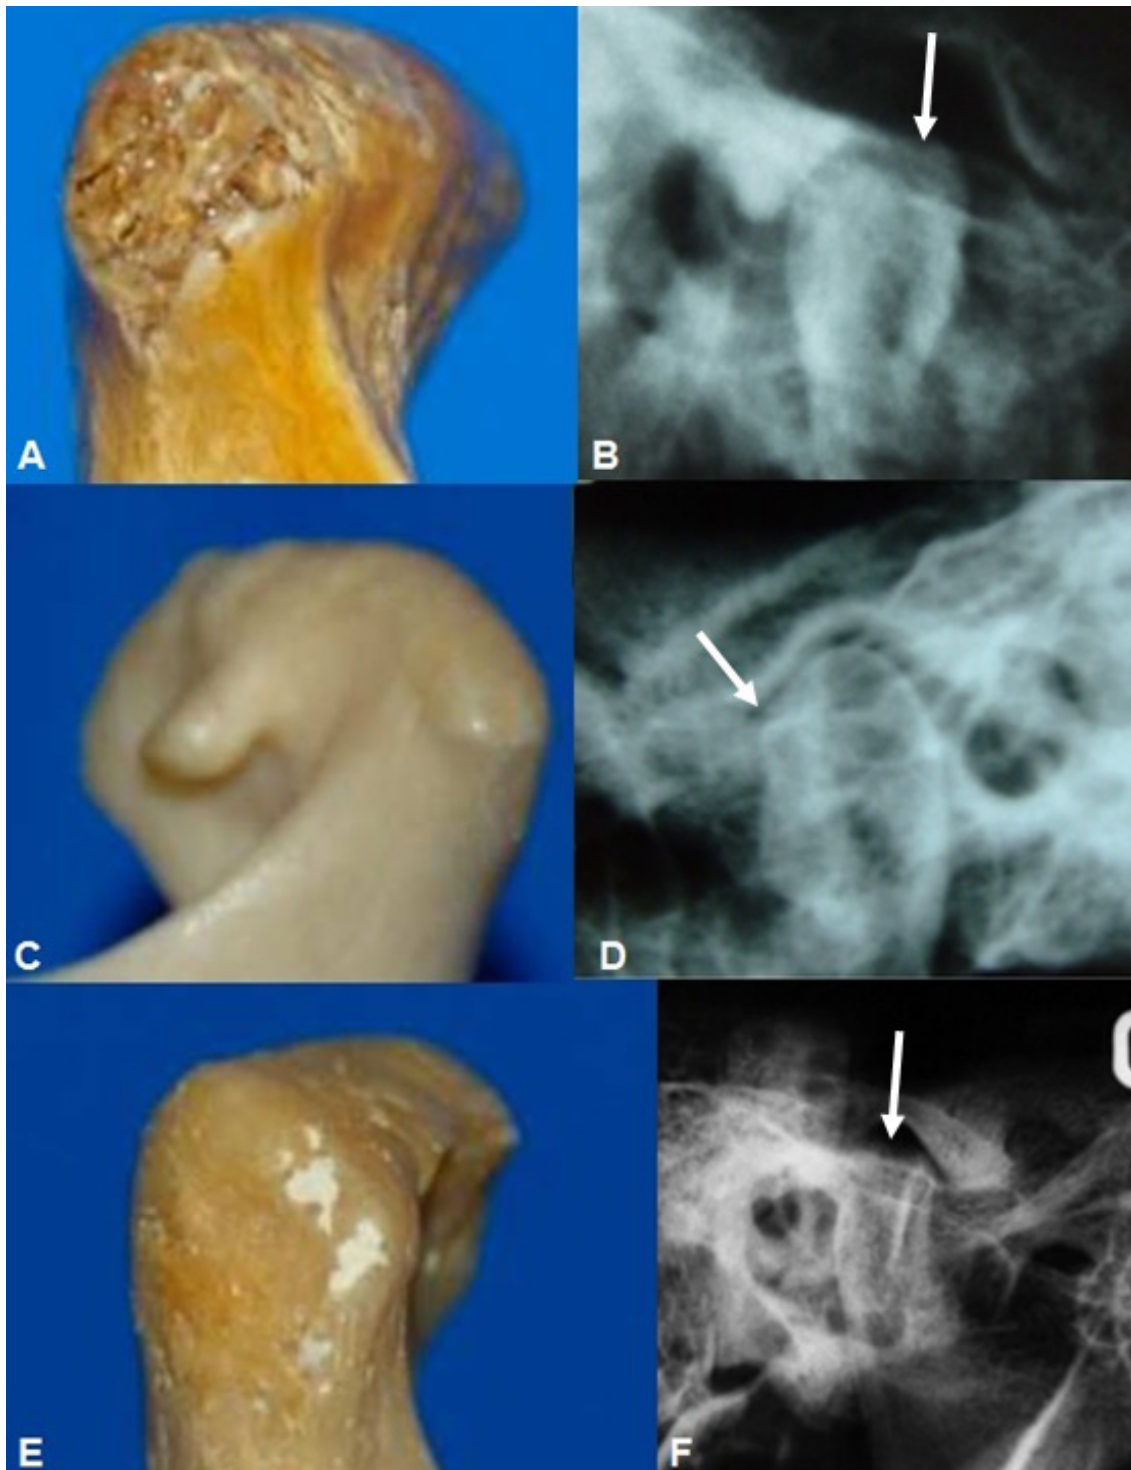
Transcranial images. A. Condyle with erosion. B. Transcranial radiograph shows the erosion. C. Condyle with osteophytes. D. Transcranial radiograph shows the osteophytes. E. Condyle with flattening of the articular surface. F. Transcranial radiograph shows the flattening
